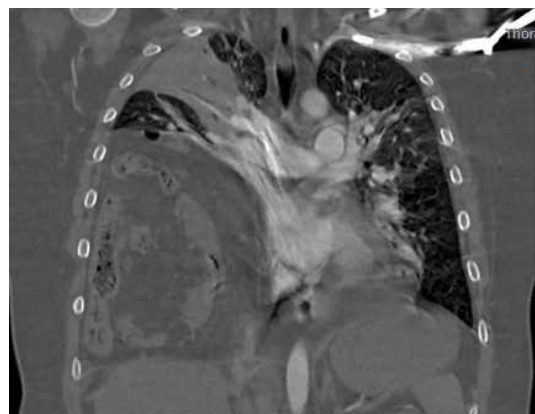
Computed tomography of the chest (coronal view) showing a large herniation of abdominal organs into the chest with compression of the right lung
